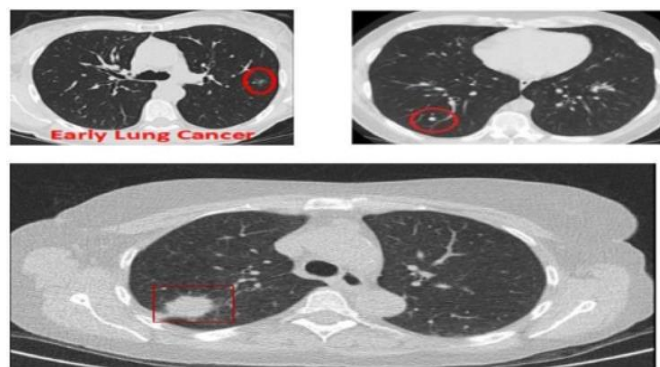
Lung Cancer CT image
